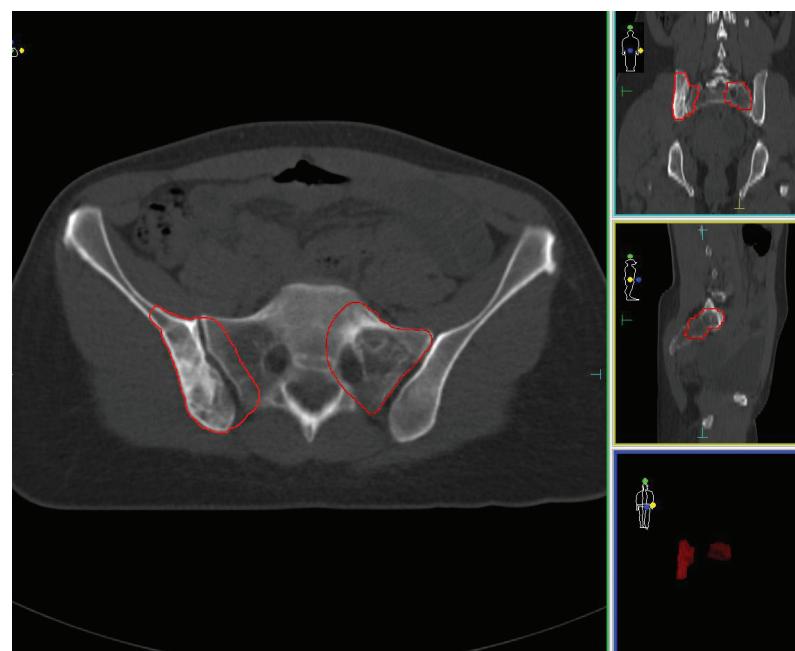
The primary localization of tumor in pelvis, CT after CT VIDE
